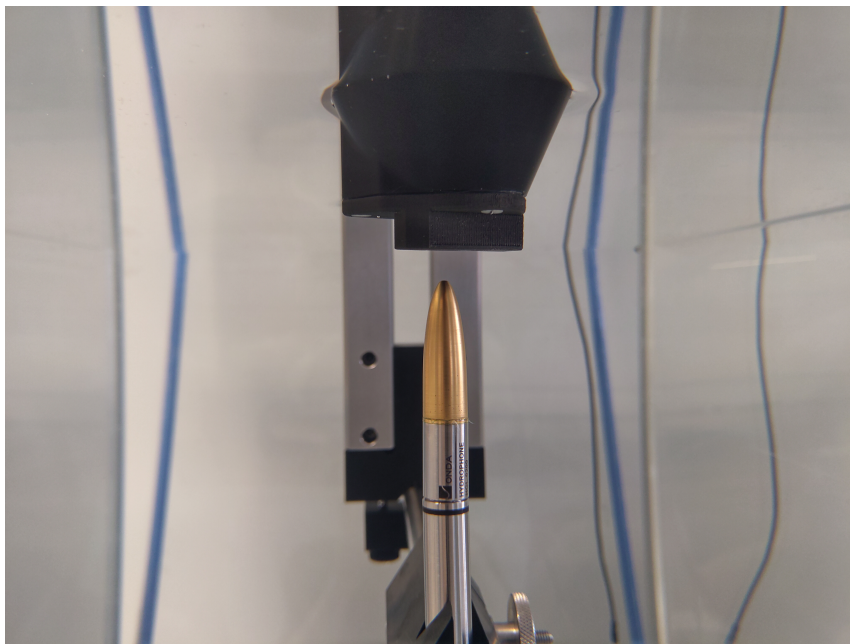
The ultrasound transport measurement setup with a custom adapter made for characterization. The setup is submerged in water, and the hydrophone is pointed towards the opening of the transducer.
